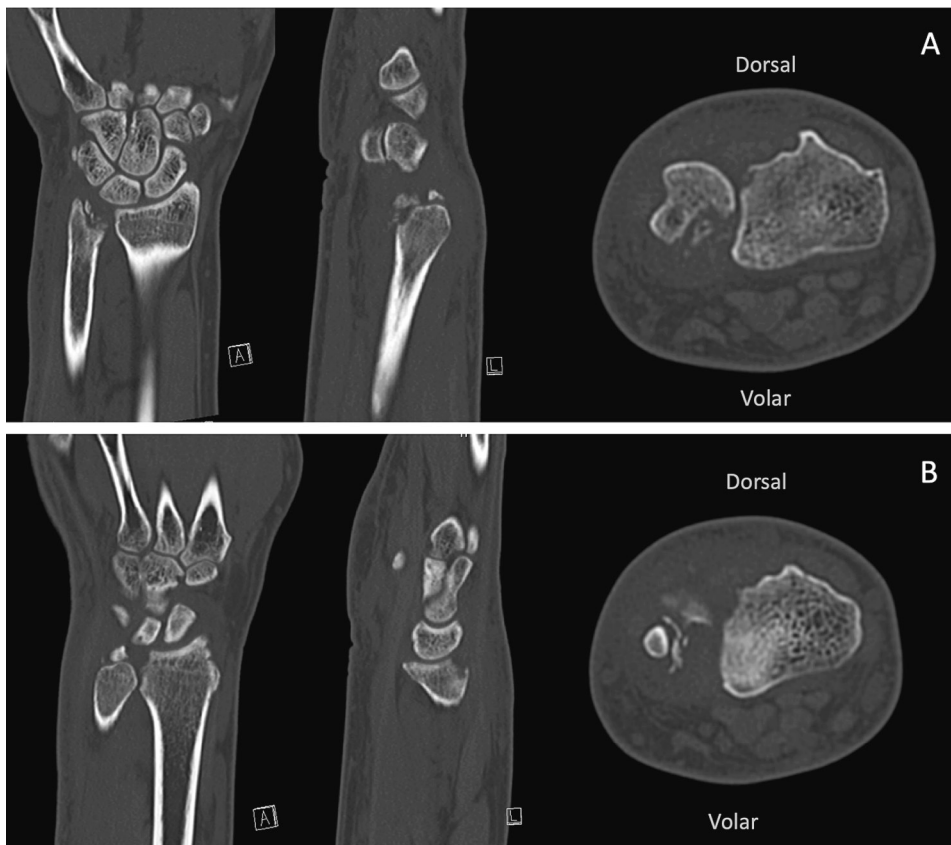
CT scan of patient's wrist (one month after initial injury).
